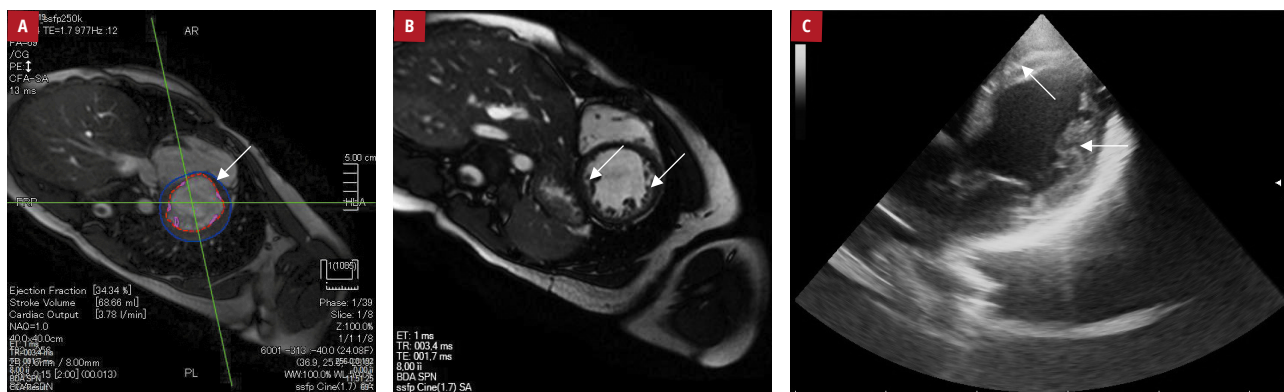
Cardiac magnetic resonance imaging (A, B) and echocardiography (C) showing left ventricular noncompaction. The arrows show the pathological hypertrabeculation of the left ventricle with 2 myocardial layers—normal and noncompacted
